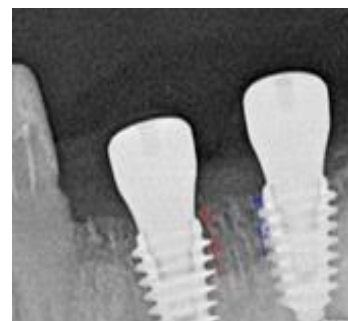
X-ray after surgery
